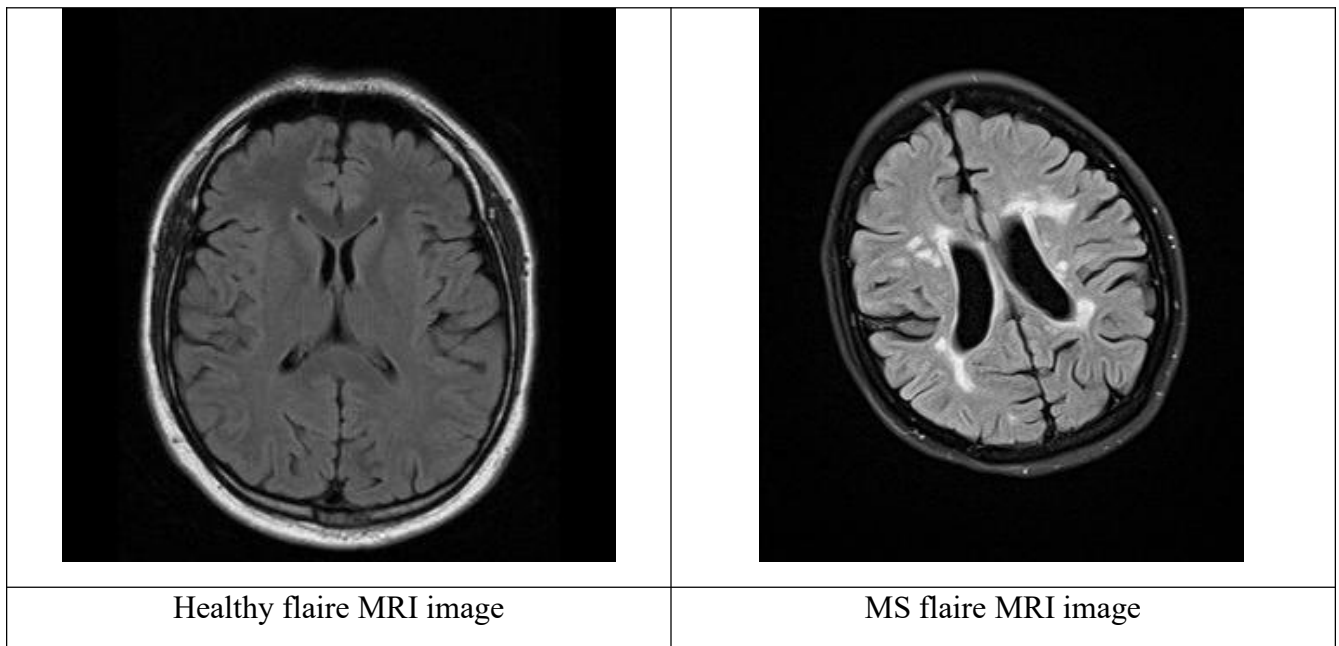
Representative FLAIR MRI samples from the MS and Healthy classes.
